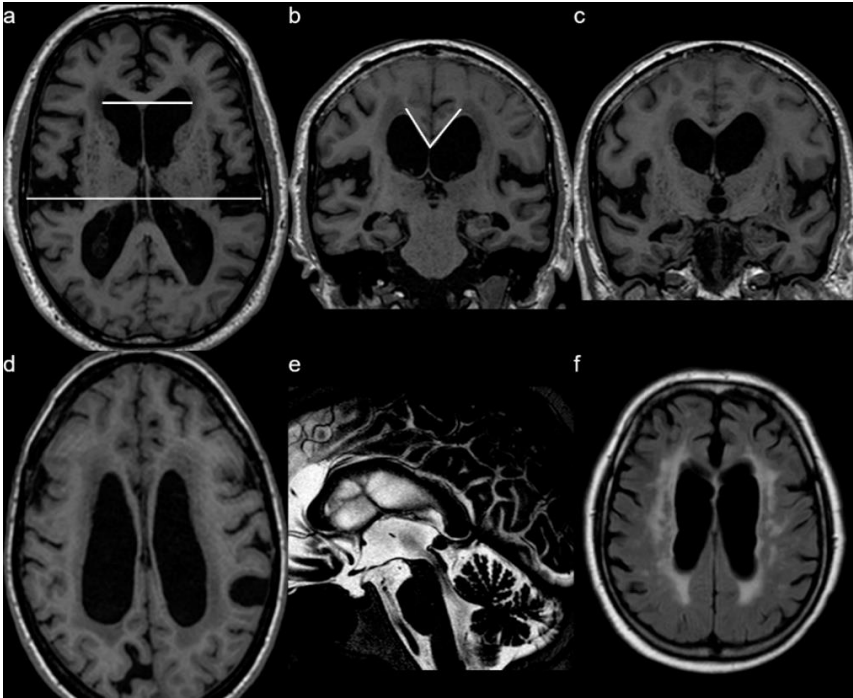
Example of morphological measurements and signs in iNPH. The Evans' index (a), and corpus callosal angle (b) on T1-weighted images. A combination of dilated Sylvian fissures and compressed sulci at the high convexity – DESH (c), and focally dilated sulci (d) on T1-weighted images. A present flow void sign in the cerebral aqueduct on a T2-weighted image (e), and periventricular as well as deep white matter hyperintensities on a T2-FLAIR image (f).
